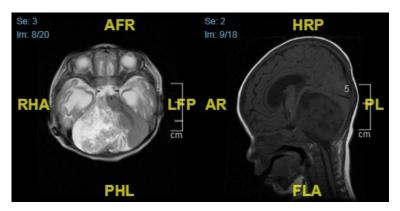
Large intra-axial posterior fossa tumour seen on initial MRI imaging with obstructive hydrocephalus
